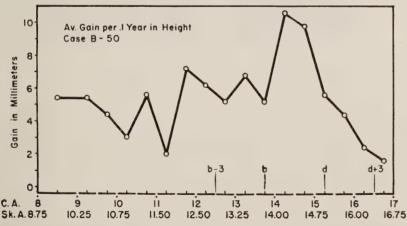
This figure shows the height growth profile for Case B50, whose X-ray photographs appear in Figure 132b, and indicates the relation between skeletal age and chronological age at the developmental points for height.
